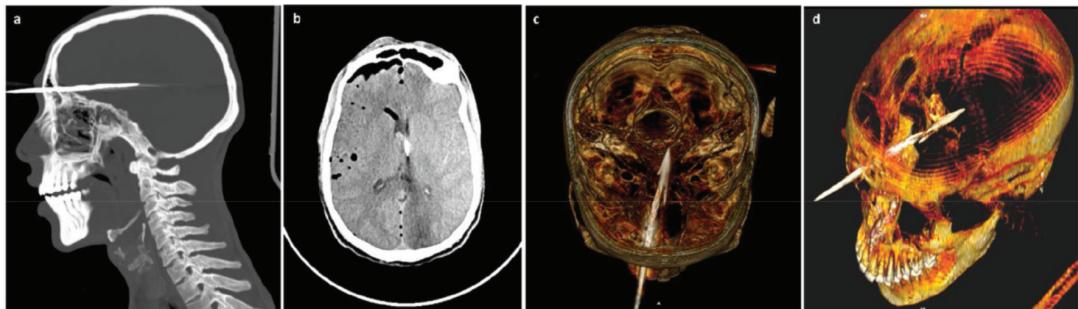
(a)(b) - CT scan of Male, 35 Injured by arrow through the forehead, arrow penetrates right frontal sinus and tip terminates near the left basal ganglia. Pneumocephalus and air within the ventricles (c)(d) - 3D model of the CT image for better visualization.
